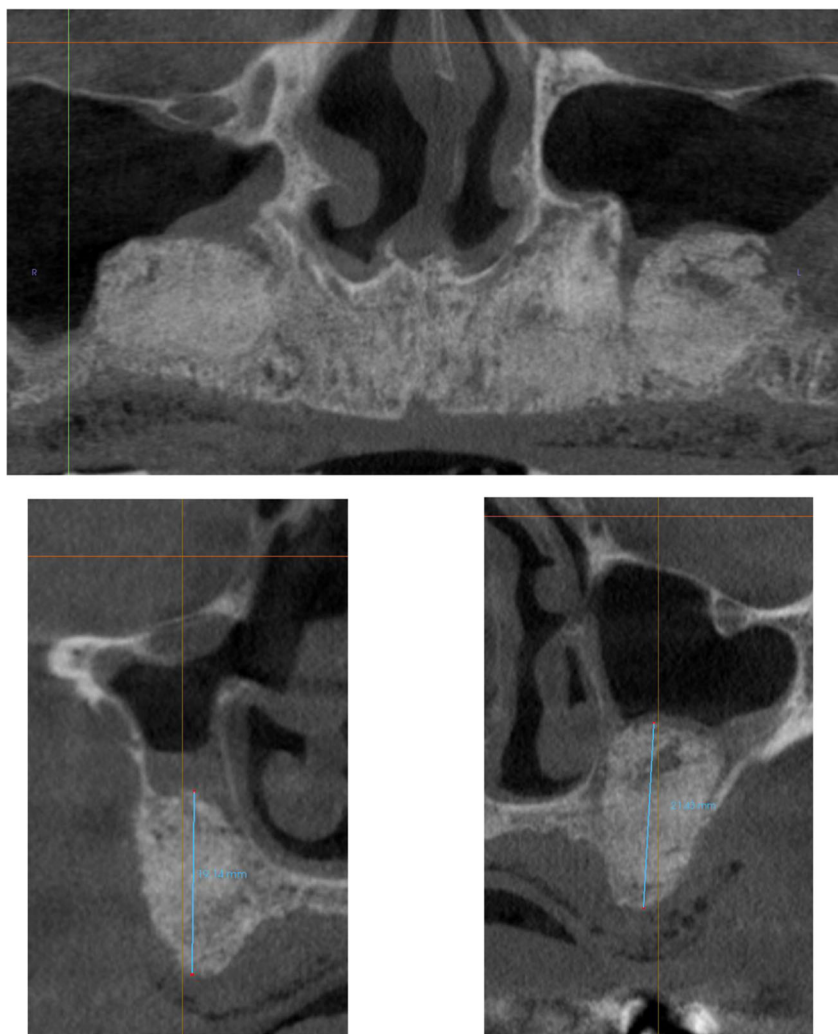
CBCT obtained 6 months post sinus augmentation
